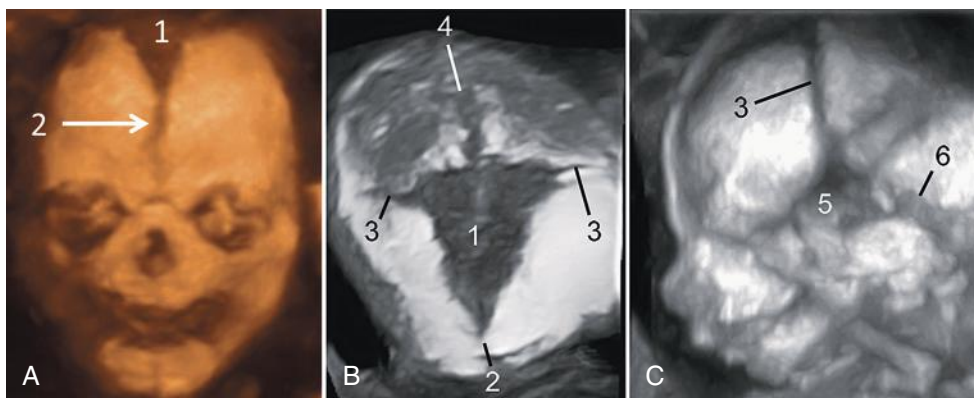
Three-dimensional ultrasound image showing skeleton of the face and skull using maximum/transparent mode. The different sutures and fontanelles are depicted in the coronal (A), superior (B), and lateral (C) views of the skull: 1, bregmatic fontanelle; 2, frontal or metopic suture; 3, coronal suture; 4, parietal suture; 5, sphenoid fontanelle; 6, mastoid suture.
